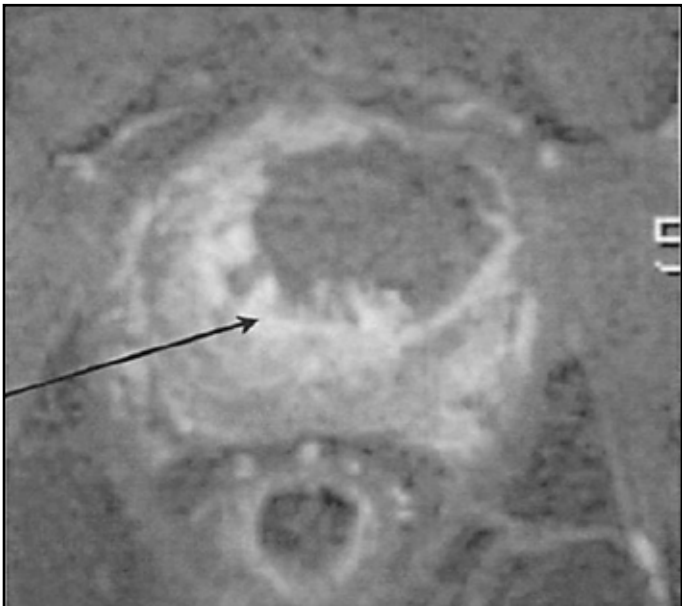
MRI image following NanoKnife therapy showing complete ablation of the tumorous area. Arrow point to the ablated tumour
